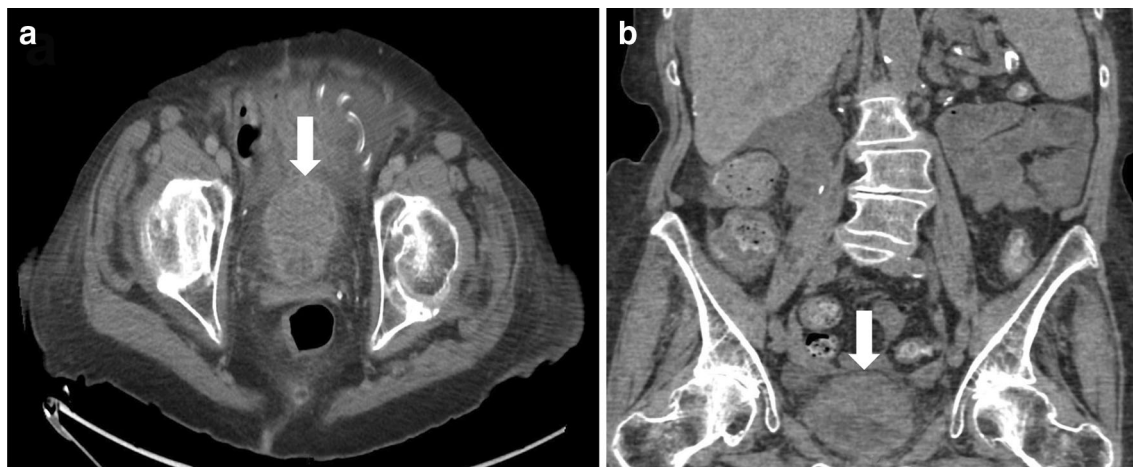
Computed tomography abdomen and pelvis with intravenous contrast demonstrates a small urinary bladder with thickened cystic wall in both axial (a) and coronal (b) views (white arrows)
